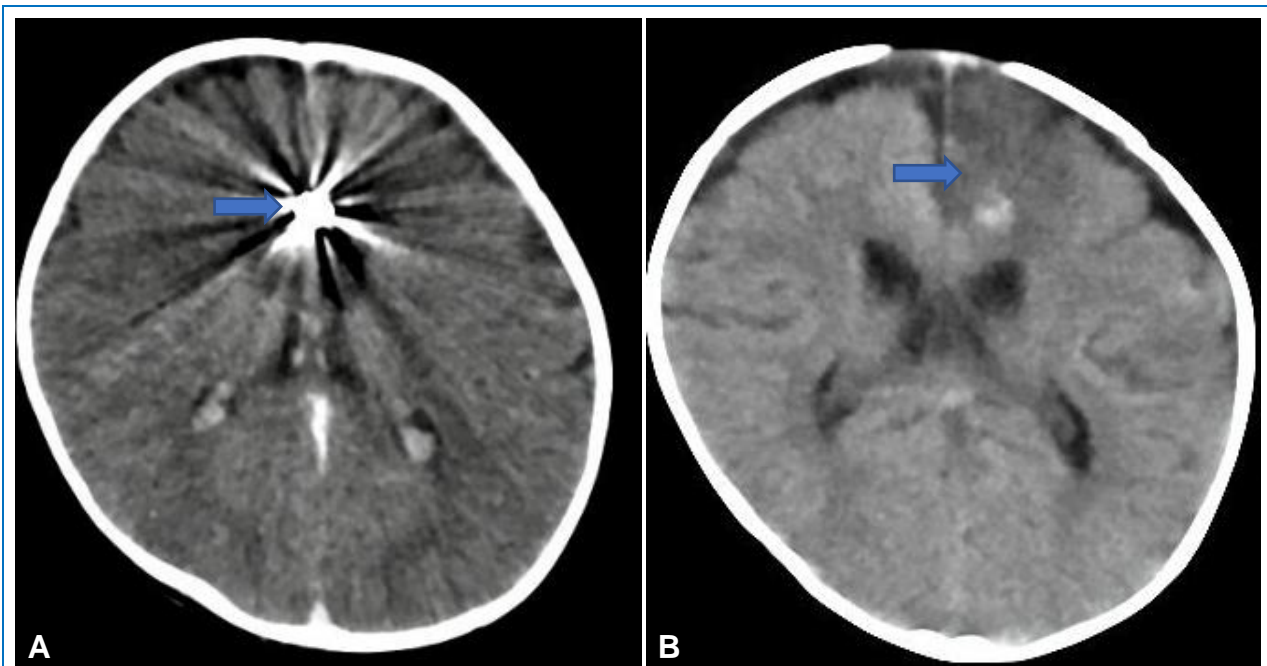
(A) Brain CT without contrast in axial section showing the hyperrefringence of the embolization material in the territory of the left A2-A3 segment (blue arrow). (B) Brain CT without contrast in axial section showing infarction in the territory of the left pericallosal artery (blue arrow) that did not cause major clinical repercussions.
